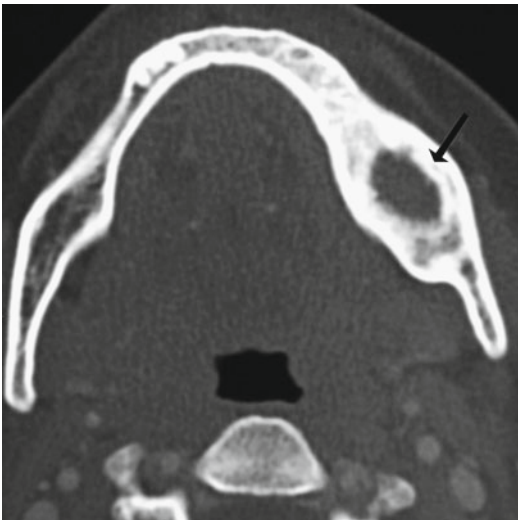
CT scan: ossifying fibroma of the left ramus of the mandible in a young patient with hyperparathyroidism-jaw tumor syndrome
